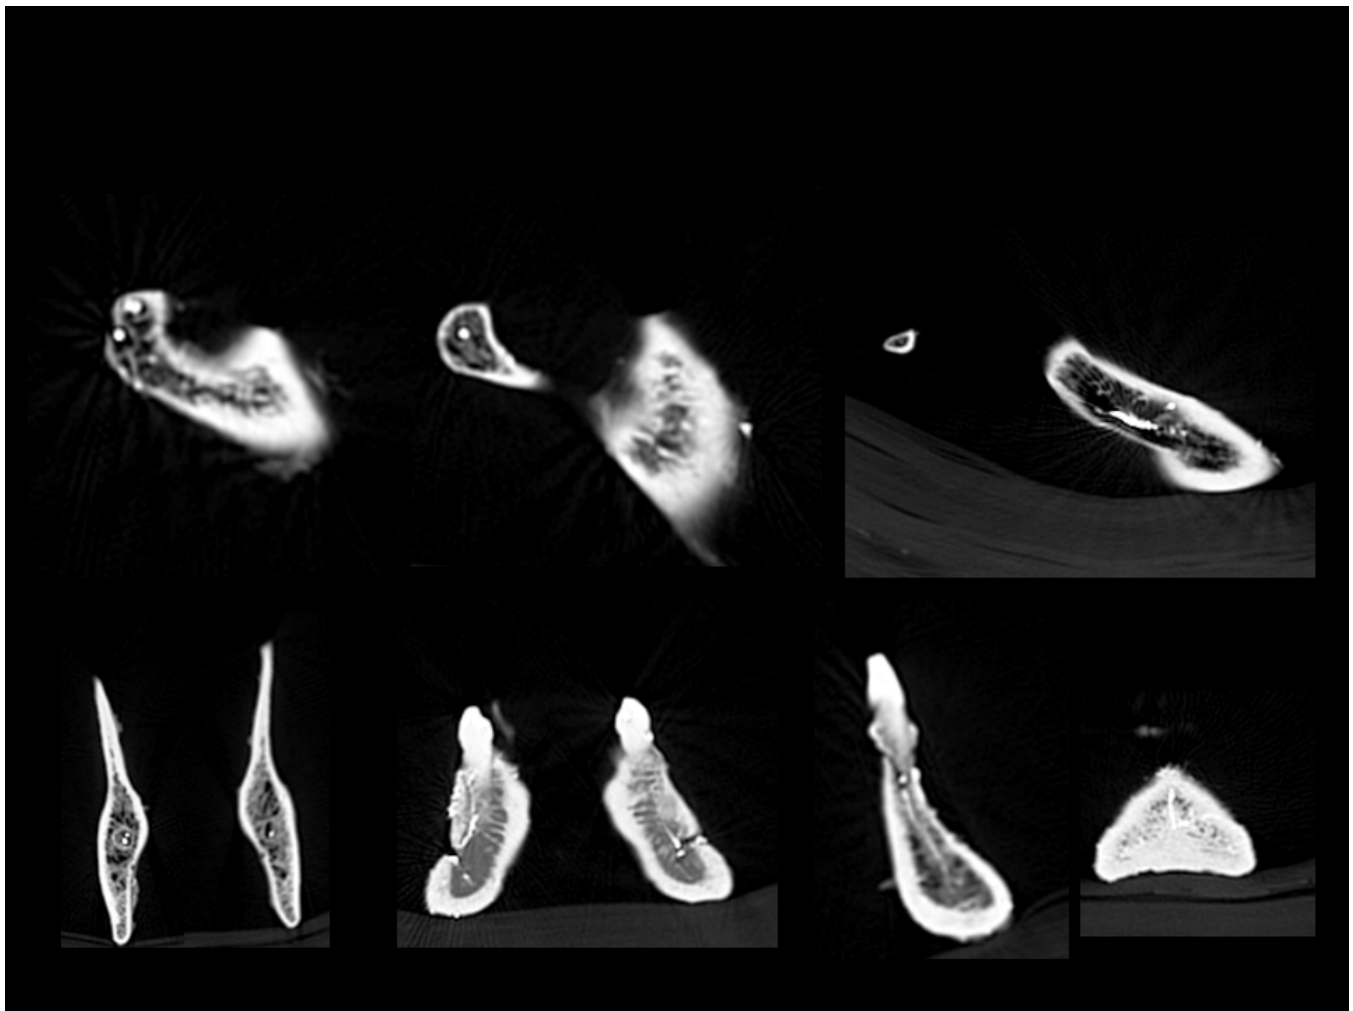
CT scan of the mandible after injection of the lead oxide gel in the right facial artery confirms the presence of contrast at the level of condyle, coronoid process, ramus, angle (within the inferior alveolar canal), mental foramen and symphysis (*From top left to bottom right*). Central canal arteries to the teeth and affluents to the periodontal dentogingival plexus contained the contrast.
